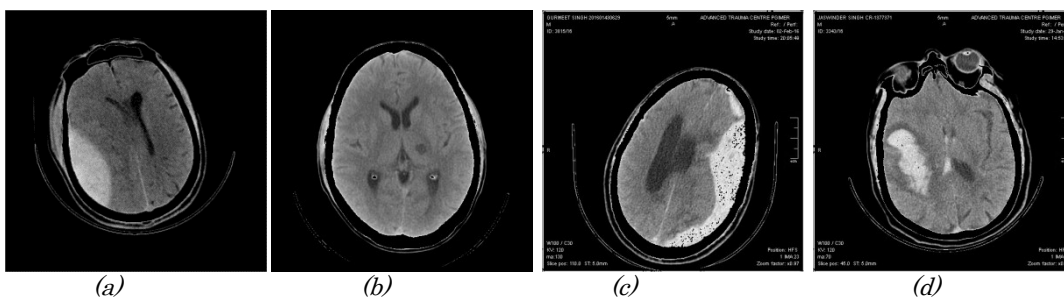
CT scan after skull thresholding
